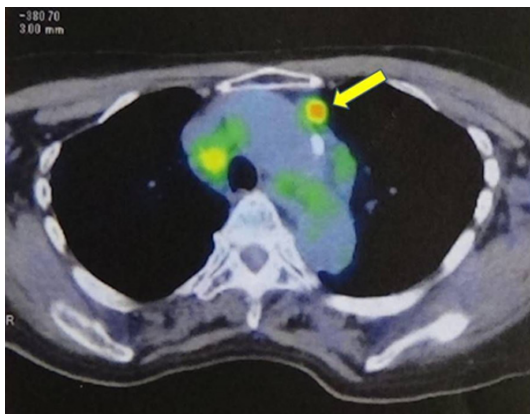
FDG-PET (axial section) for initial staging before treatment showing increased FDG uptake in the multiple mediastinal lymph nodes (SUVmax=4.9) (arrow). In contrast, no FDG uptake was seen in the cervical or any other LNs. FDG-PET did not afford a clear distinction between metastatic lesions and sarcoidosis.
